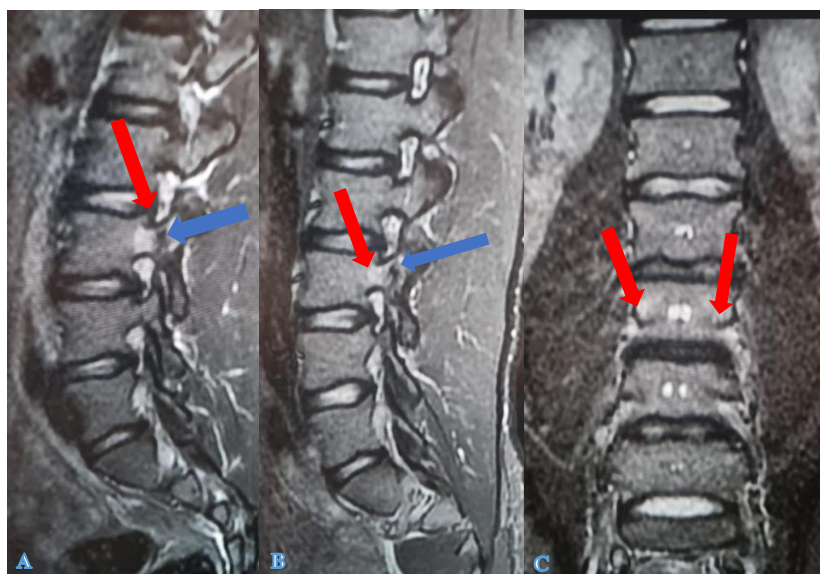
A-B): Flair sagittal MRI scans (A right, B left) documenting the post-traumatic edema at the pedicle level (red arrows), and the longitudinal stress fracture line (blue arrows); C): coronal MRI scan: confirmation of pedicle stress fractures (red arrows).
